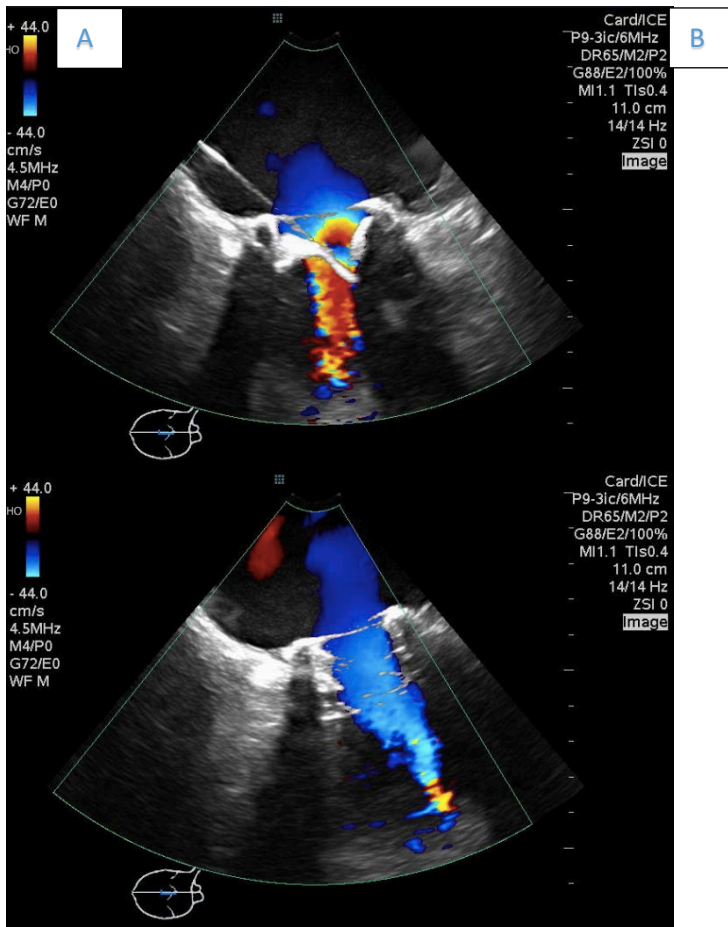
A) Intracardiac echocardiogram reveals moderate tricuspid regurgitation, and severe tricuspid stenosis with limited leaflet mobility. B) Post valve-replacement, no tricuspid regurgitation or perivalvular regurgitation is noted.
